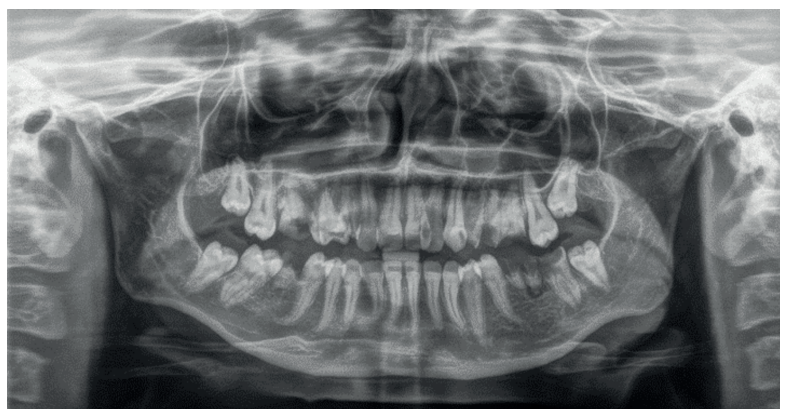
Pre-operative panoramic radiographic image (right).
